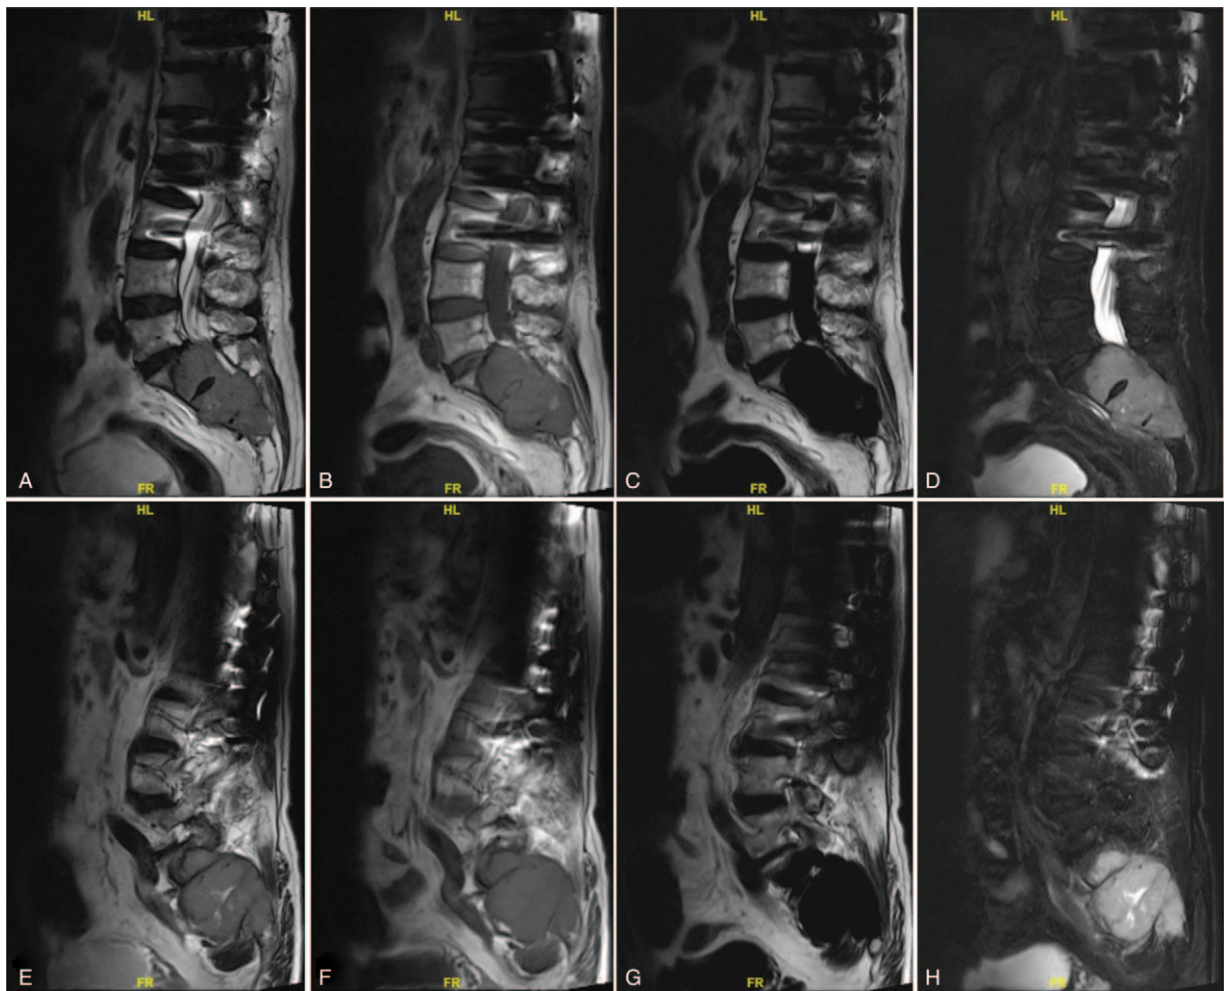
(A–H) Preoperative sagittal MRI scan revealing the density of soft tissue measuring 10 cm × 7.5 cm × 5.7 cm, obvious bony destruction in the sacrum, and spinal cord compression caused by metastatic malignant thymoma, with increased metastatic marrow infiltration of the sacrum. MRI = magnetic resonance imaging.
